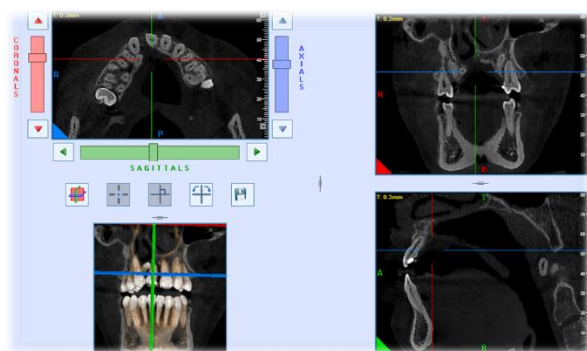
CBCT image giving precise information about the volume of the defect, position of the impacted teeth in an unilateral cleft palate case
